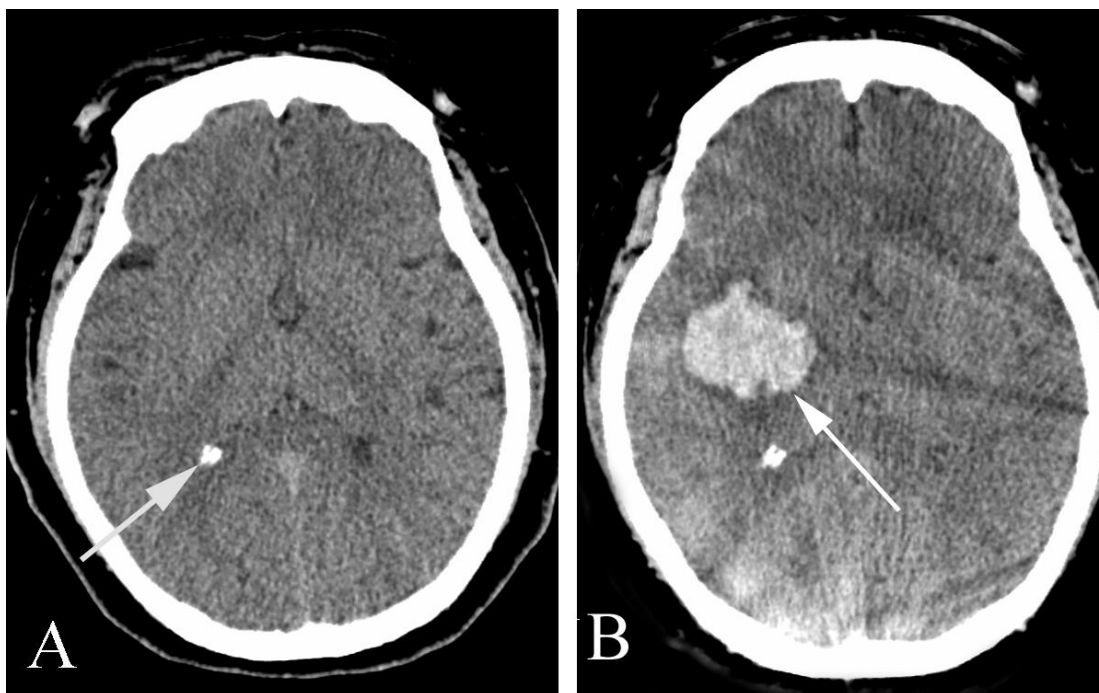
Intraparenchymal hematoma in a 51 year old with headache and slurred speech along with left-sided weakness. A. Axial unenhanced CT study done six months previous to the development of headache and neurologic symptoms demonstrates normal brain parenchyma. Incidentally noted are (normal) calcifications of the choroid plexus in the right occipital horn of the lateral ventricle (arrow). B. Axial unenhanced CT done at the time of the headache and neurologic symptoms demonstrates an acute hemorrhage into the right basal ganglia (arrow).
